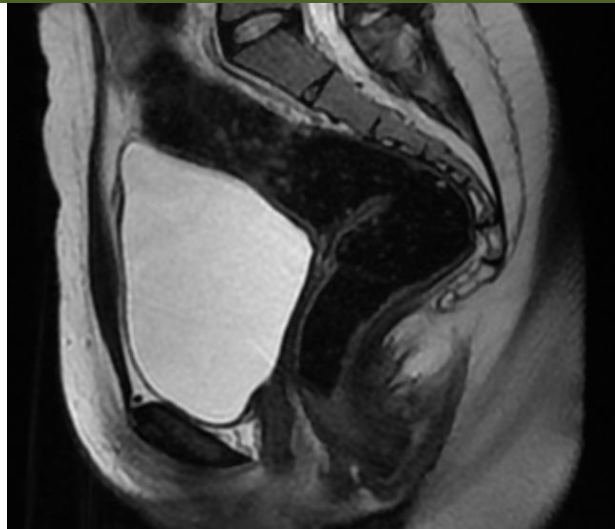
Sagittal T2-weighted MRI image from Case 2 demonstrating complete agenesis of the uterus and upper two-thirds of the vagina
